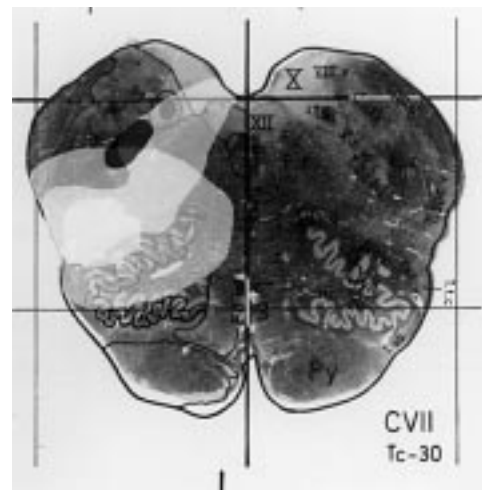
Superimposed MRI slices of three patients with normal blink reflexes at level 30.0. Lesions of patients with normal blink reflexes were located more ventrally compared with patients with abnormal blink R2-i/R2c-i.
